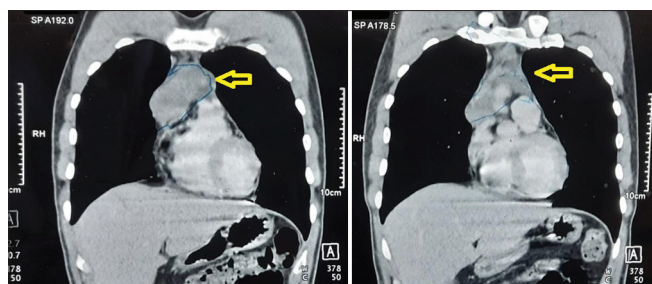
Computed tomography thorax showing the anterior mediastinal mass
